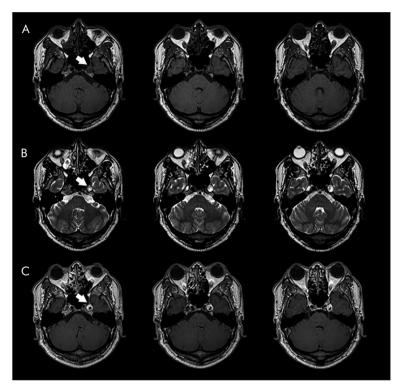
The patient's thin-slice, gadolinium-enhanced MRI, which revealed a $1.1 \times 1.2 \times 1.3$ cm, well-defined, lobulated mass (arrow) compressing the trigeminal nerve in the left Meckel's cave (arrow). The lesion was slightly hypointense on T1-weighted imaging (A) with inhomogeneous high-signal intense on fat suppression T2-weighted imaging (B), and it showed intense enhancement with focal cystic change (C)
